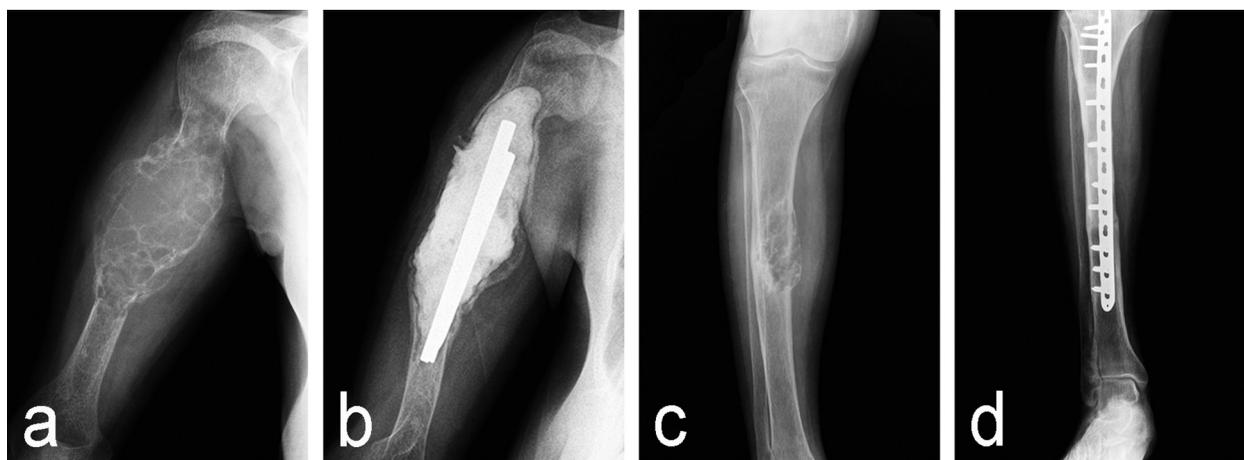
A case of a multicentric GCTB: a) preoperative antero-posterior radiograph of a diaphyseal GCTB of humerus; b) AP radiograph after extended intralesional curettage and cementation reinforced with Küntscher nails; c) preoperative AP radiograph of a diaphyseal GCTB of tibia; d) AP radiograph after segmental resection and structural allogenic bone grafting.
